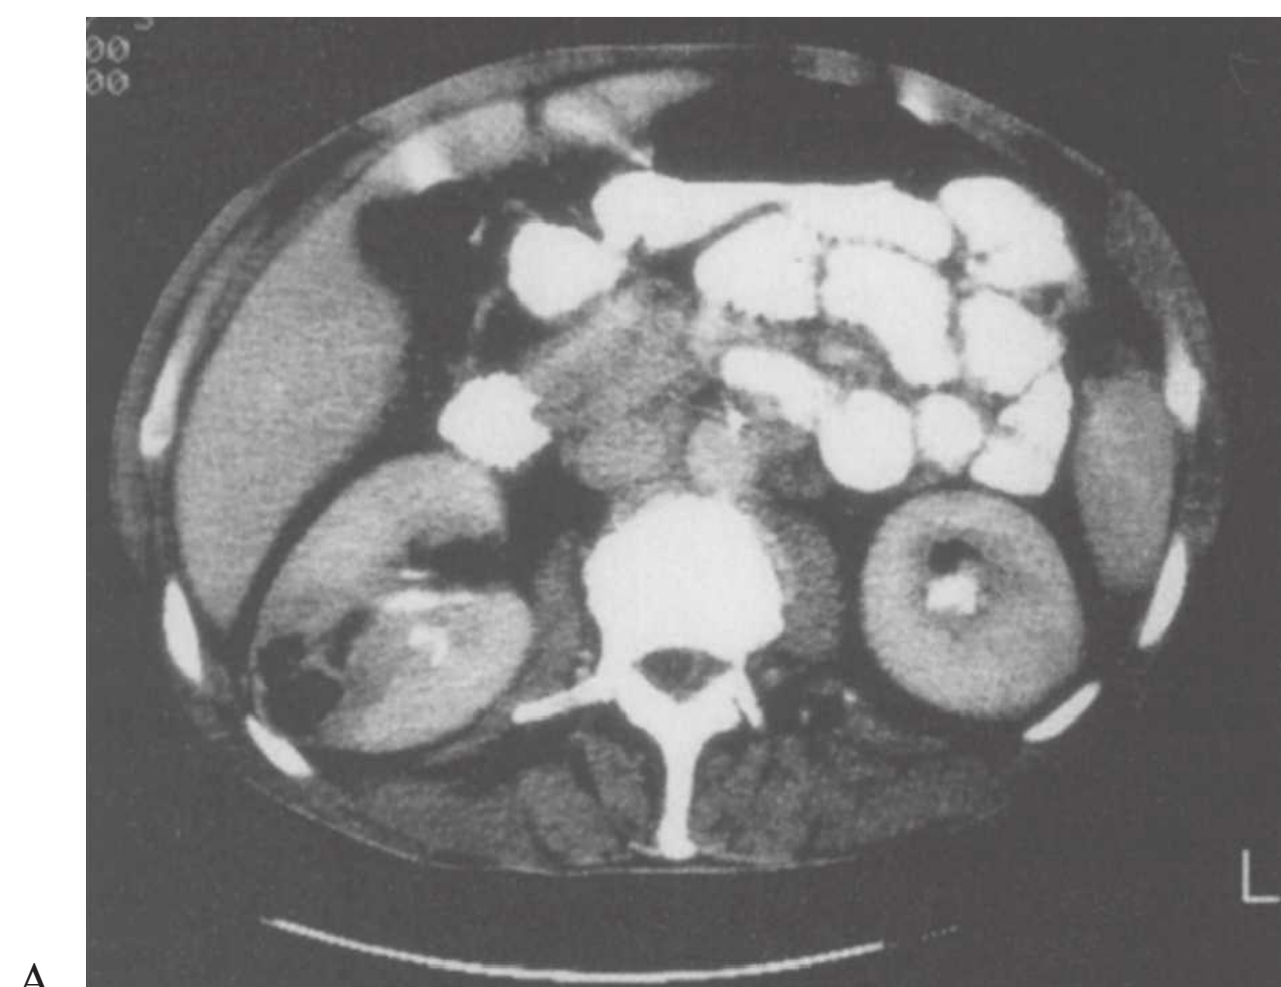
Computed tomography scans of a patient with bilateral intrarenal abscesses.
